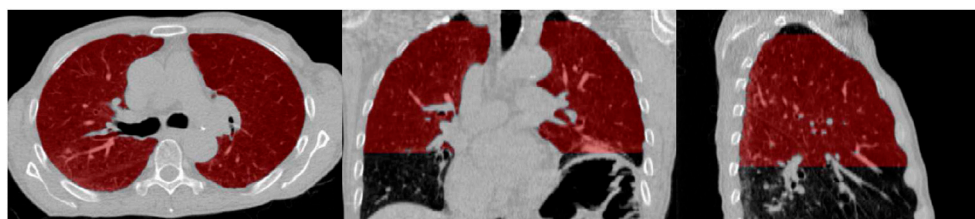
Mask used to measure attenuation variation in lung tissue, shown on frame 50% of the planning CT.
